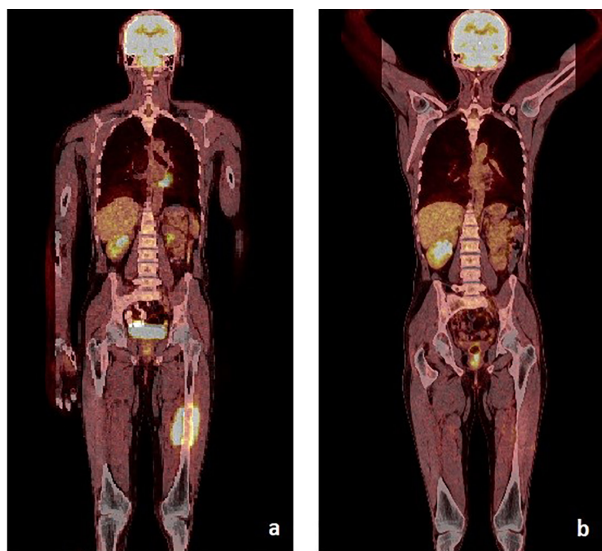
PET-CT images at initial EMR diagnosis (a) and after GO treatment (b).
